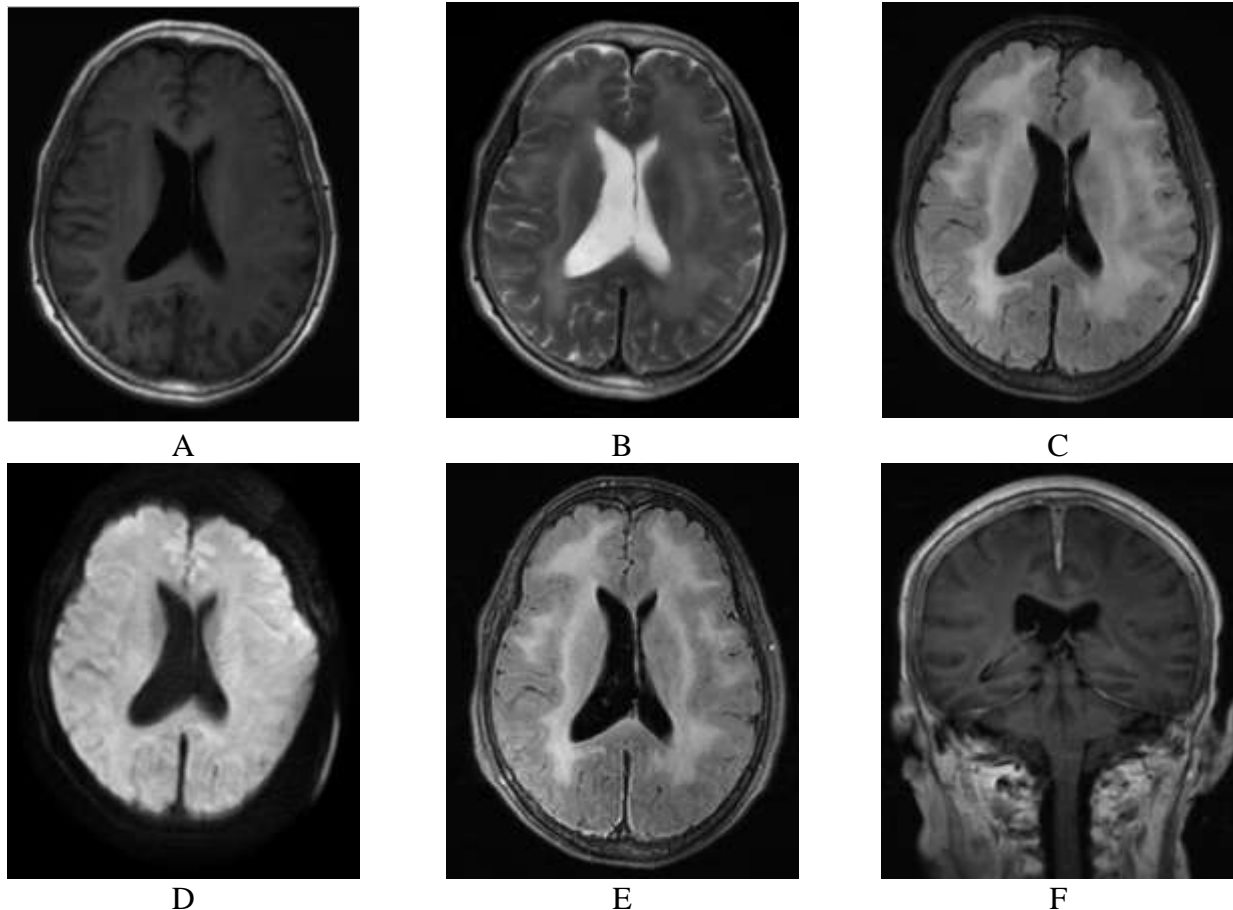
No abnormal signal intensities were identified on the T1-weighted sequence (A) and the DWI sequence (D). Extensive abnormal signal intensities in the cerebral white matter were visualized on the T2-weighted (B) and T2 flair sequences (E). Marked enhancement of extensive regions of the cerebral white matter (E) and meninges was observed on the contrast-enhanced sequences (F).
